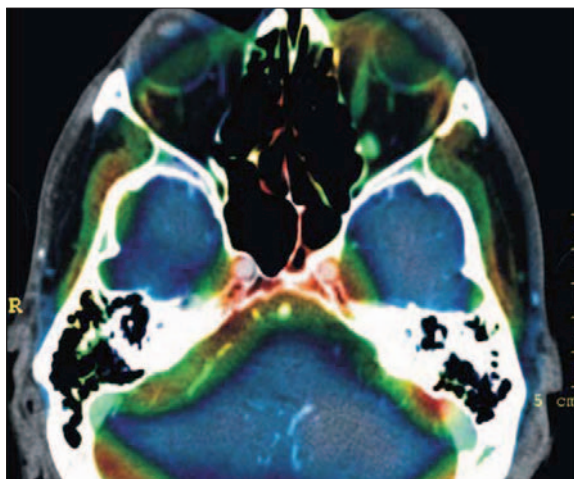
SPECT/MR fusion. Increased accumulation of labeled erythrocytes in the upper-medial part of the left orbit.
